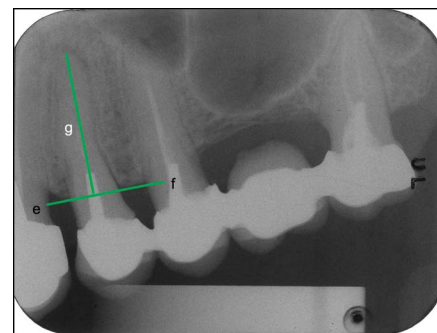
Measurement of the root on periapical radiograph prior to extraction from a reference line (green line: e-f) through the most coronal mesial and distal periodontal attachment points to the apex of the root: length of the root (green line: g).
